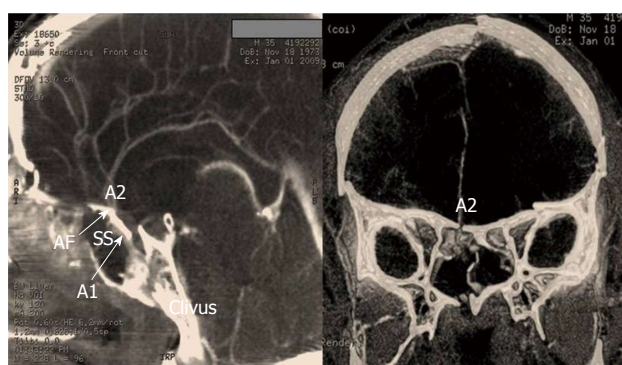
Multislice computed tomography angiography showed occlusion of the anterior cerebral artery adjacent to a fracture in the anterior fossa. AF: Anterior Fossa; A1: First segment of anterior cerebral artery; A2: Second segment of anterior cerebral artery; SS: Sphenoid sinus.
